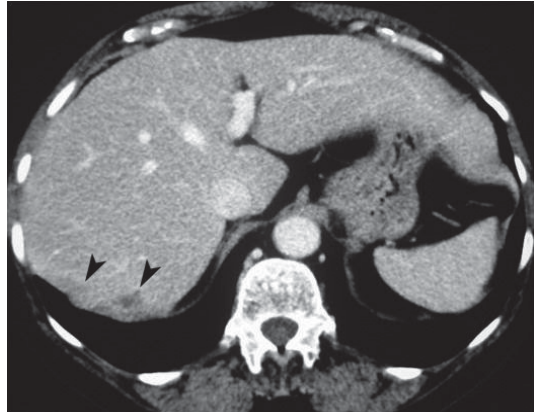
Computed tomography. Neoplastic implants of the hepatic capsule (*arrowheads*) causing retraction and irregularity of the hepatic margin
